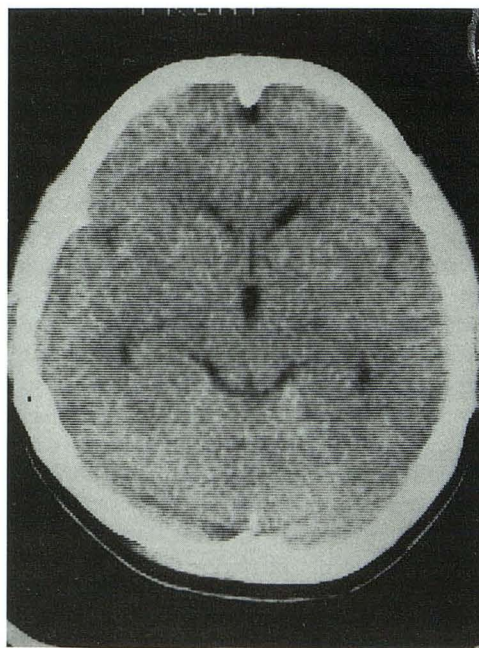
Plain CT of the brain (September 4, 1989). Clinically the patient had severe headache, vomiting, neck stiffness, and bloody CSF. There was no visible subarachnoid hemorrhage on the CT scan. However, there was slight dilatation of the temporal horns of both lateral ventricles, suggesting that the patient had subarachnoid hemorrhage at that time.
